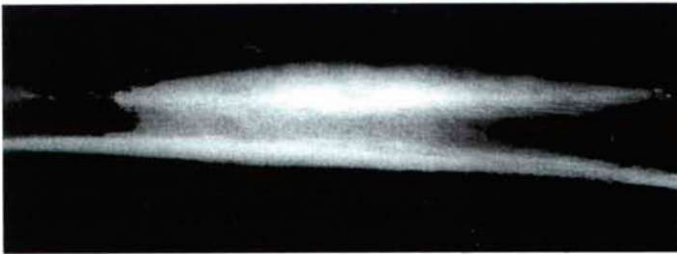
AP radiograph of the left tibia, which reveals cortical sclerosis of the diaphysis with periostitis and focal areas of bone destruction (X-ray by M. PANUEL).
